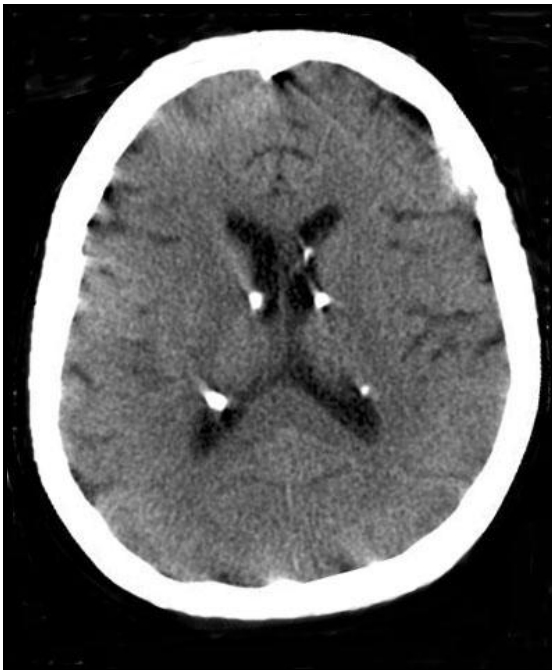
Cranial CT showed subependymal nodules.
